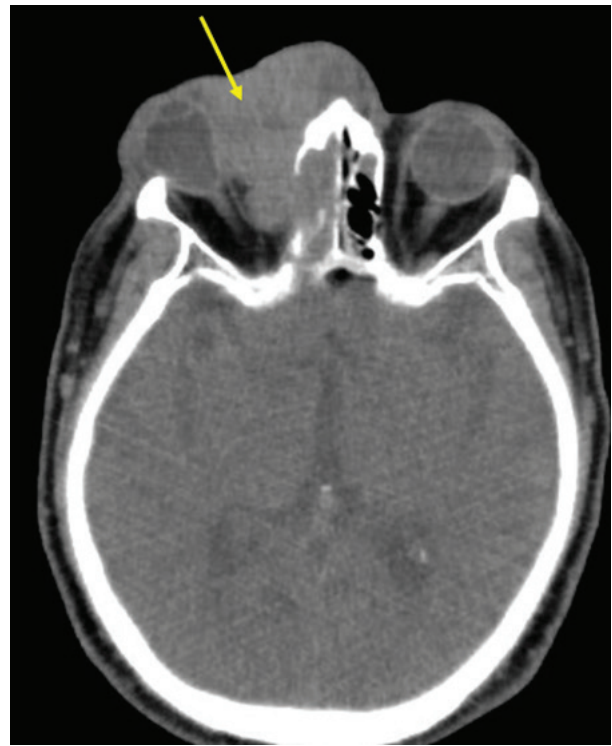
Computed tomography revealed an irregular mass extending from the right forehead to the nasal root, involving the right eyelid, medial orbit, and ethmoid sinus (yellow arrow).
